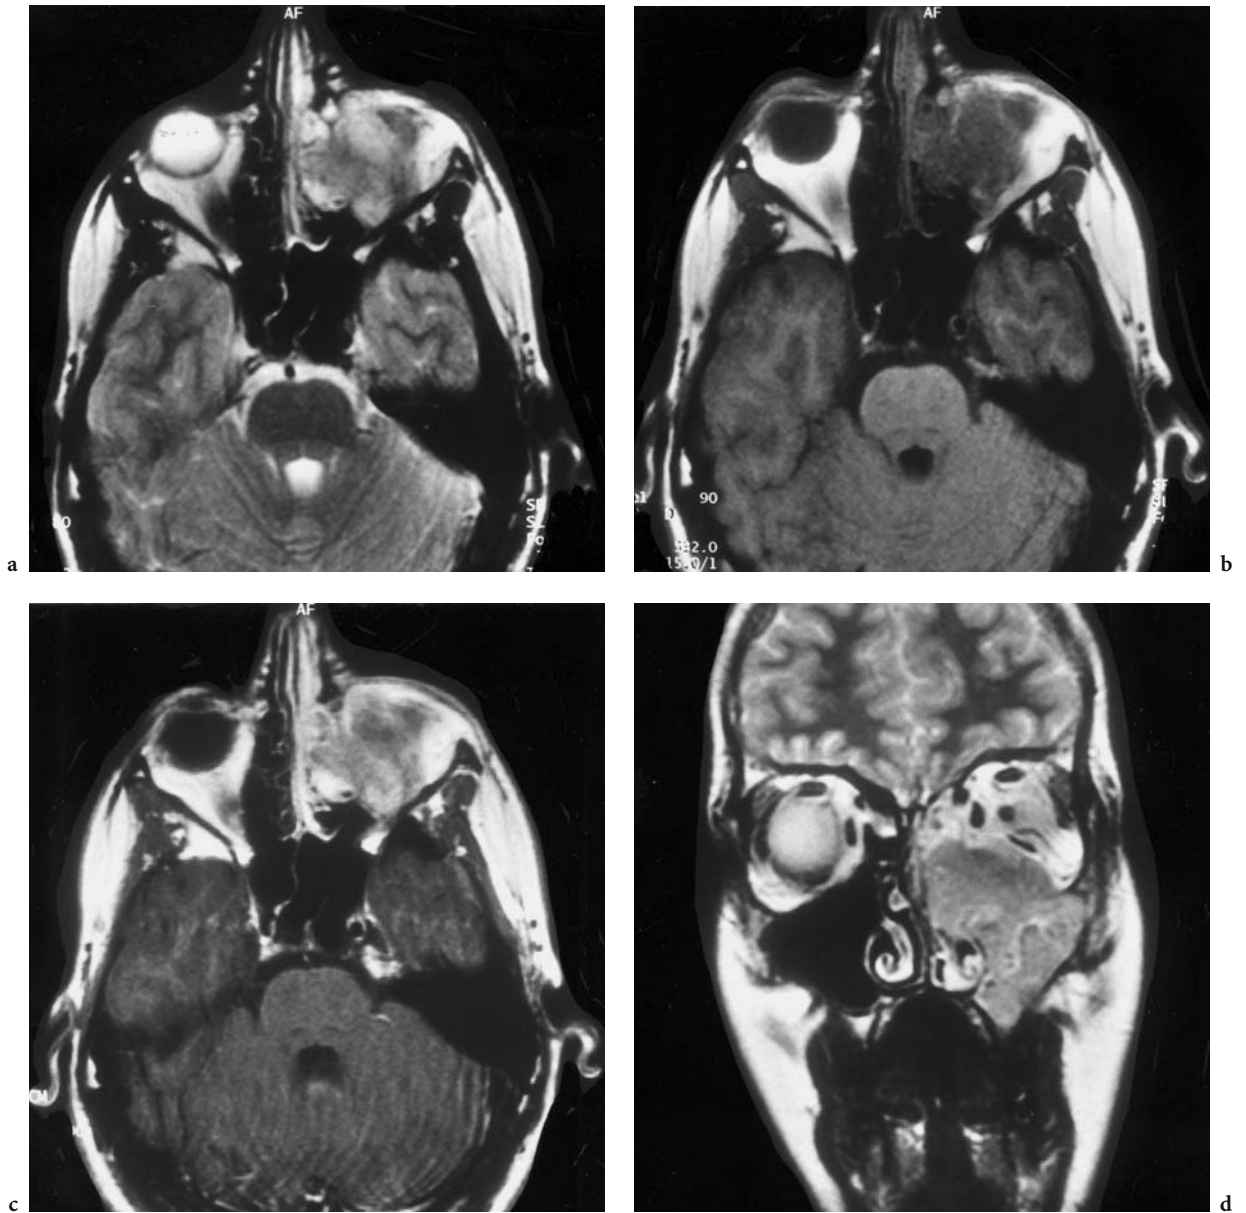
A 16-year-old man with swollen left lid and cheek. Diagnosis: rhabdomyosarcoma of the left maxillary sinus. MRI: a Axial T2-weighted view with inhomogeneous mass in the left nasal cavity and inferior orbit, displacing the inferior rectus muscle. b Corresponding T1-weighted native view. c Corresponding T1-weighted, contrast-enhanced view with moderate signal enhancement. d Coronal T2-weighted view showing the entire tumor. Inferior invasion of the left orbit, apparently without infiltration of the muscle cone
